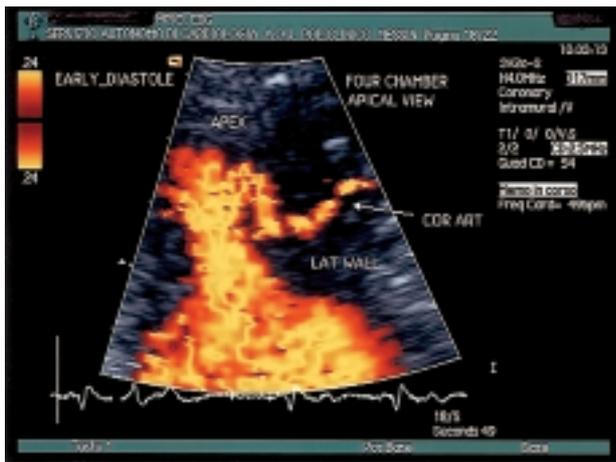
Magnified imaging of the apical region in patient D (hypertrophic cardiomyopathy with mid-ventricular diastolic obstruction). Power Doppler echocardiography reveals the presence of an intramyocardial coronary artery branch. Interestingly, a mid-ventricular size reduction starting in early-diastole can be noted. Two-dimensional image settings: transducer frequency 4 MHz; depth 17 mm; power spectrum range 24 cm/s; gain 54 dB.
